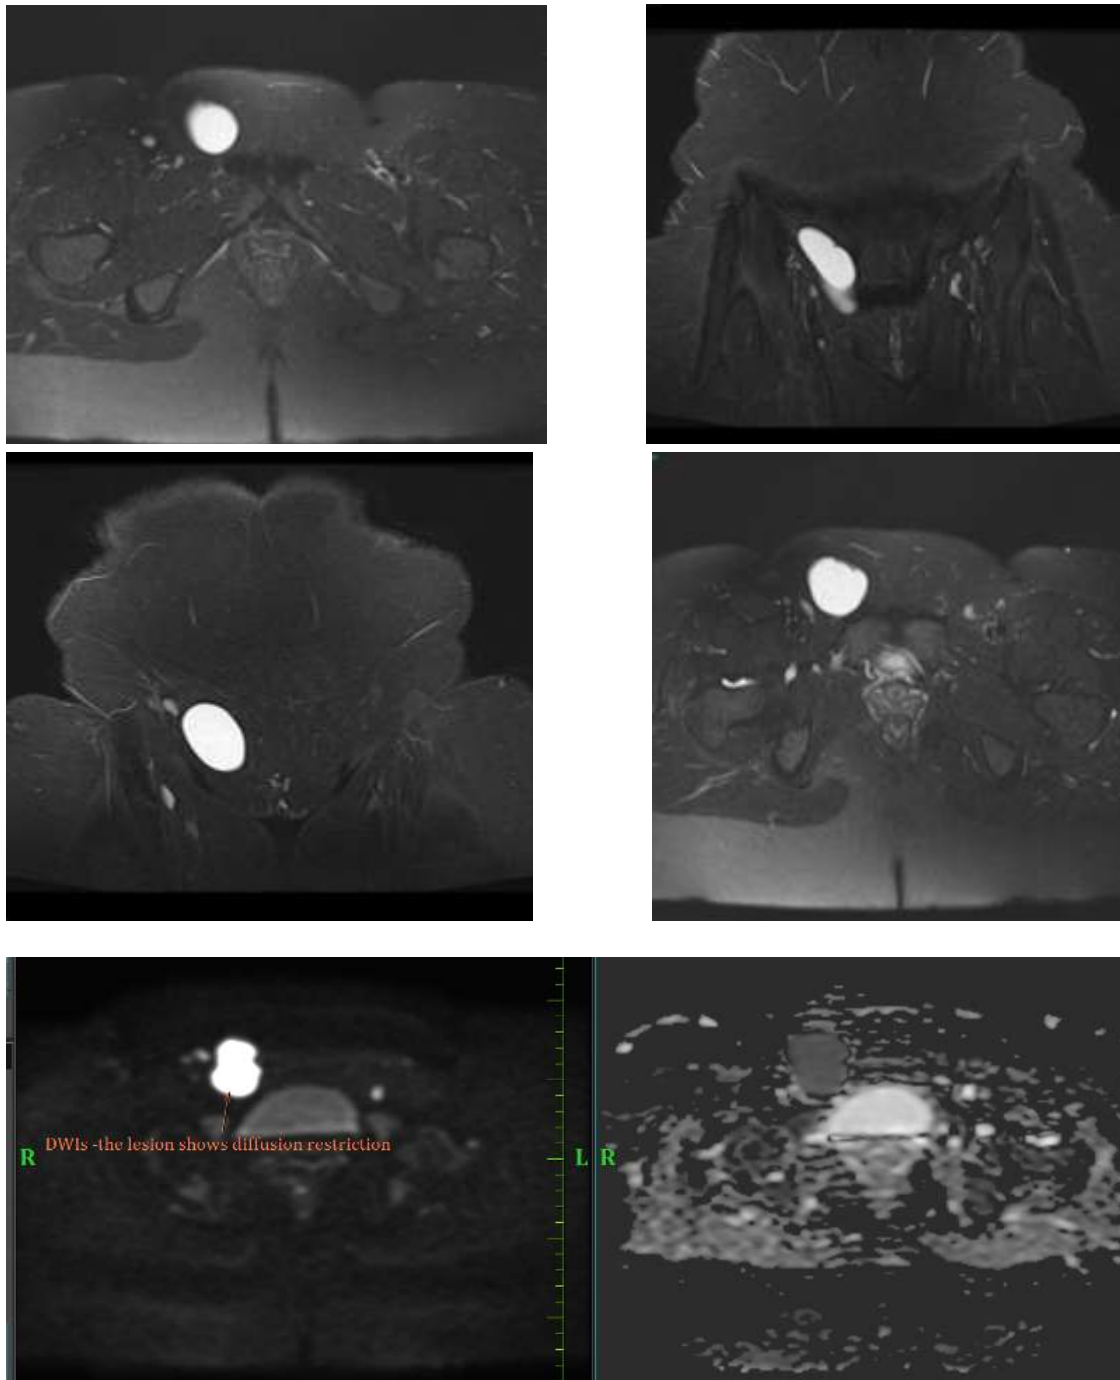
Pelvis MRI (with and without contrast) showing a thin-walled cystic structure located in the right groin.
